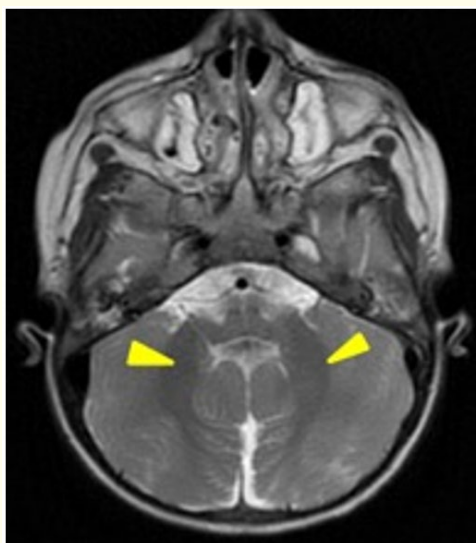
T2-weighted axial image revealing the bat wing configuration of the 4th ventricle (yellow triangle).
